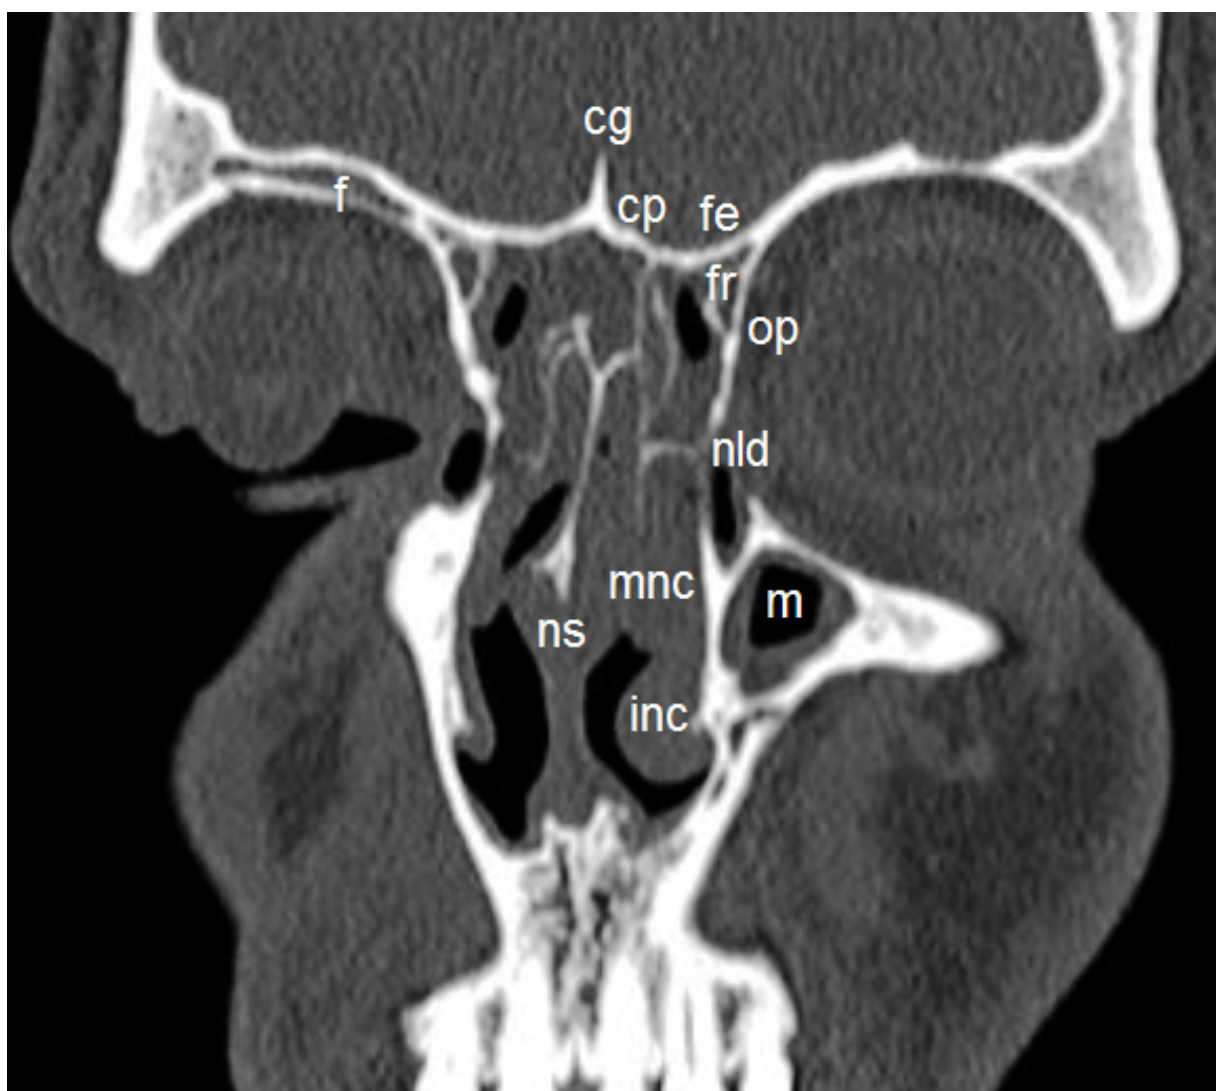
Coronal CT scan of the paranasal sinuses at the level of the nasolacrimal duct: crista galli (cg), cribriform plate of the ethmoid (cp), frontal sinus (f), fovea ethmoidalis (fe), frontal recess (fr), orbital plate of the ethmoid (op), nasolacrimal duct (nld), middle nasal concha (mnc), inferior nasal concha (inc), nasal septum (ns), and maxillary sinus (m). The figure was generated by the authors
